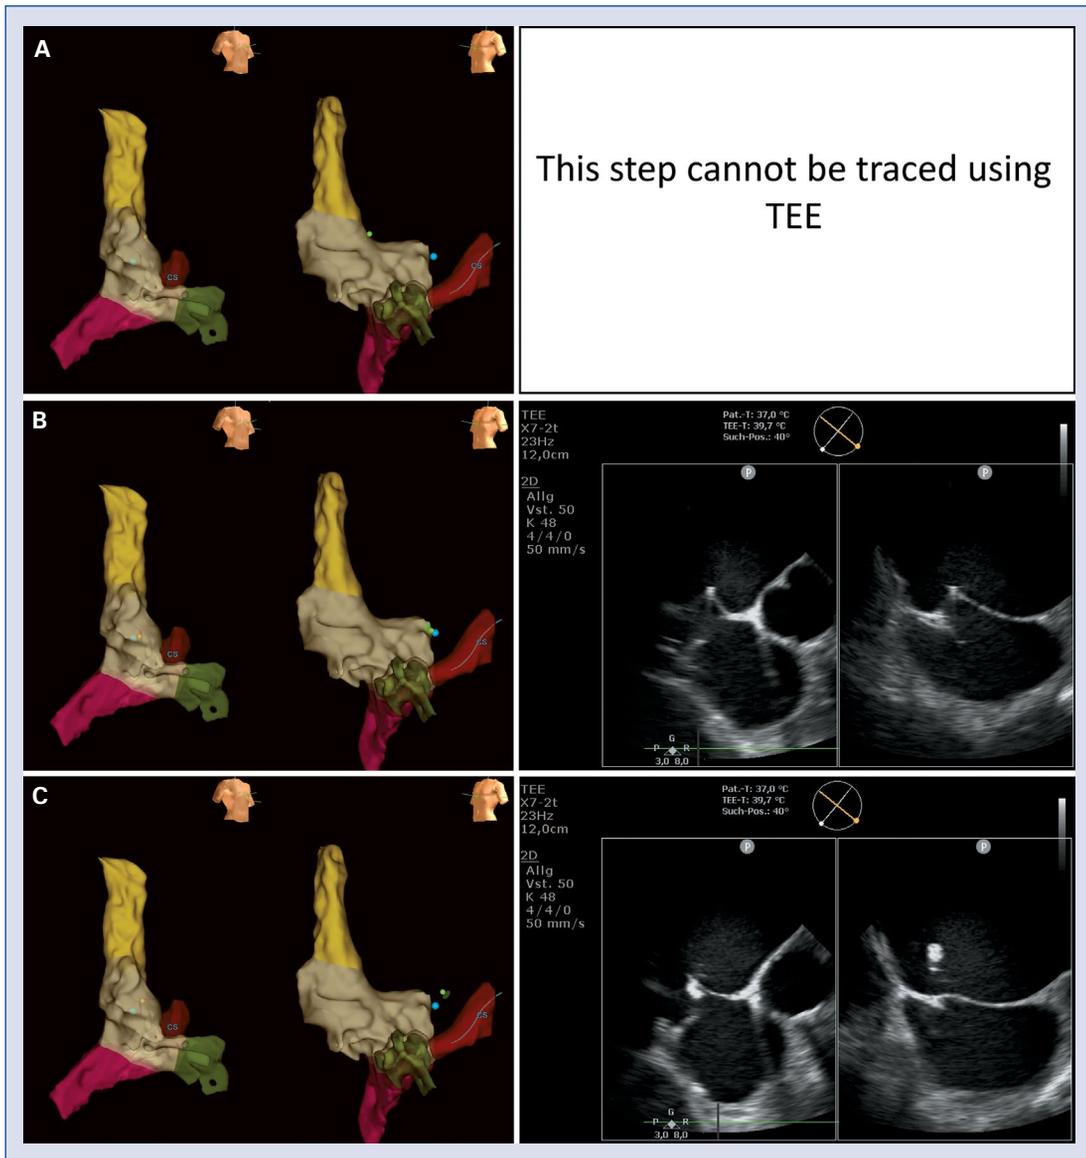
Left side three-dimensional anatomical map of the anatomical structures in the right anterior oblique and left anterior oblique projections; right atrium (grey), superior vena cava (SVC) (yellow), inferior vena cava (purple), coronary sinus (red) and right ventricle (green). The blue point depicts the ideal location for transseptal puncture, which was marked with the radiofrequency (RF)-catheter before. On the right side, transesophageal echocardiography (TEE) pictures of the interatrial septal (IAS) in short and bicaval planes; A. The RF-needle (the green point) moves from the SVC towards the IAS. This step cannot be traced using TEE; B. The tip of the RF-needle reached the desired place. The TEE picture showing the “tenting” of the IAS confirms a safe position of the needle; C. The tip of the needle is in the left atrium, out of the right atrium map. TEE pictures show specific spontaneous echo contrasting during energy application. Note, the “tenting” disappears after RF delivery.
